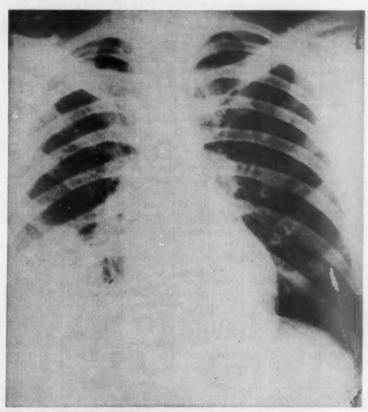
Chest x-ray of patient with typhoidal tularemia, showing extensive pneumonia in right lower lung field.
